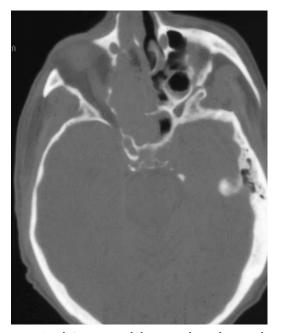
Axial CT scan with bone windows shows right sinus lesion with orbital extension due to renal cell carcinoma metastasis.
